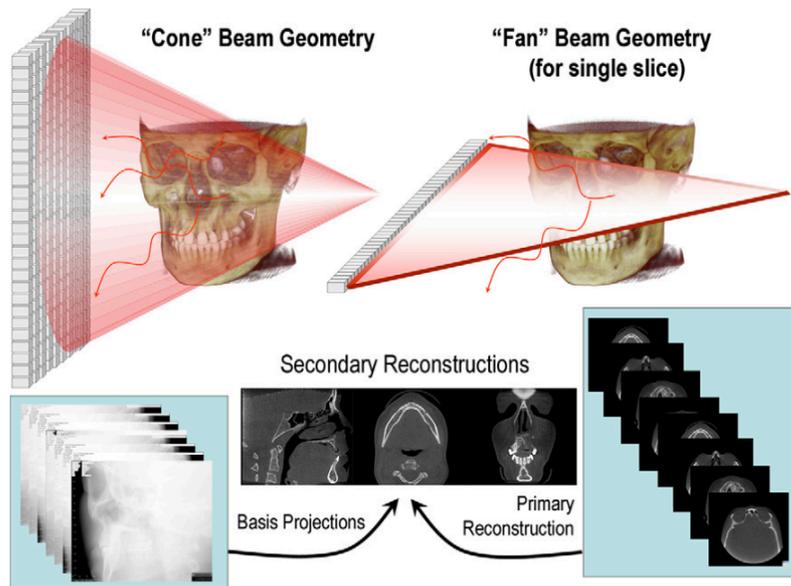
Cone-beam CT (left) and conventional CT (right) x-ray beam projection geometry and resultant image production (From Scarfe & Farman, 2008).
